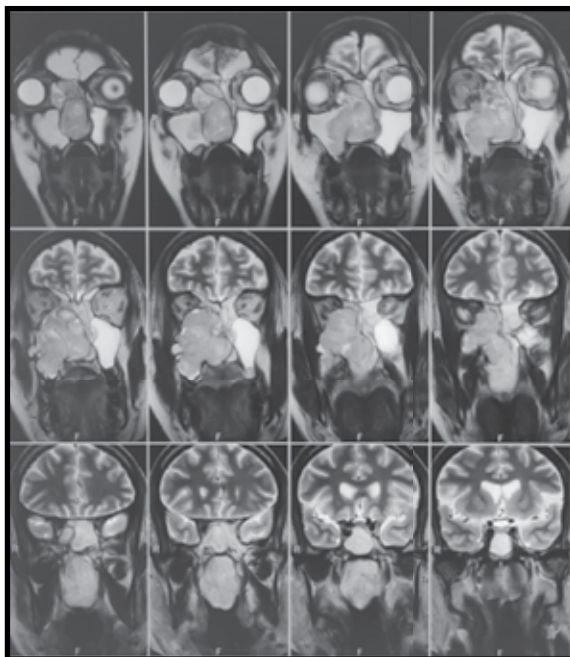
MRI appearance of the mass lesion filling up the right nasal cavity.
